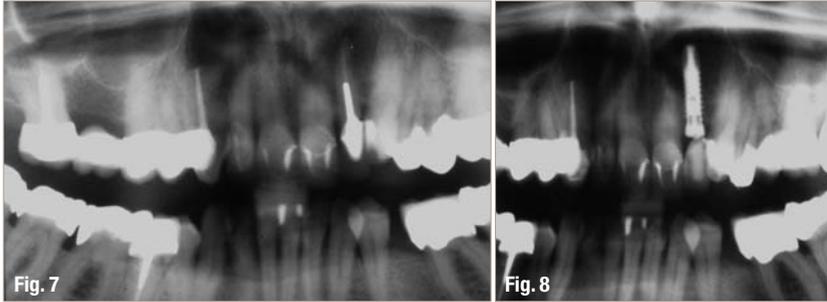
X-ray prior to extraction of 22.
